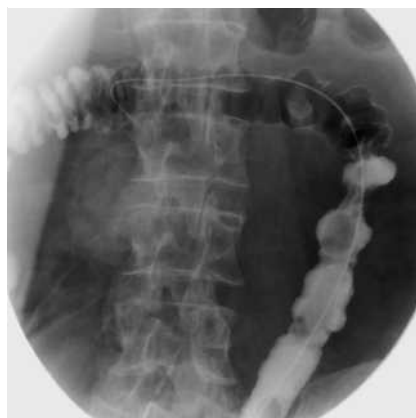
Radiograph showing the 450 cm long guide wire reaching the transverse colon. The colon is outlined with water-soluble contrast injected through transrectal puncture of the descending colon.
